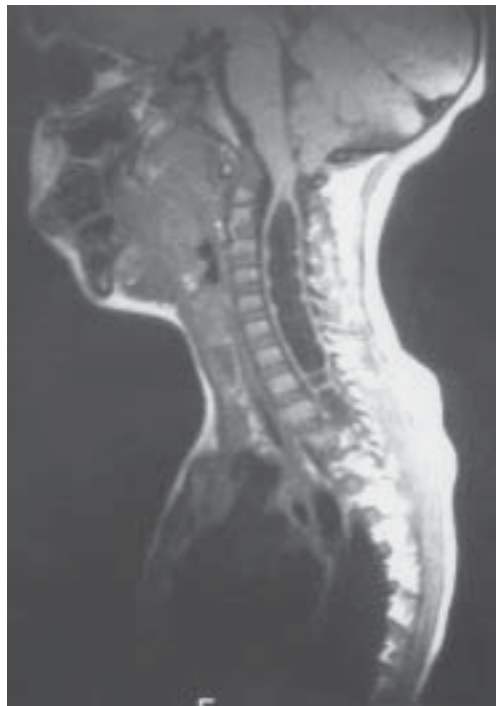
Sagittal MRI revealing holocord Chiari I syringomyelia.
